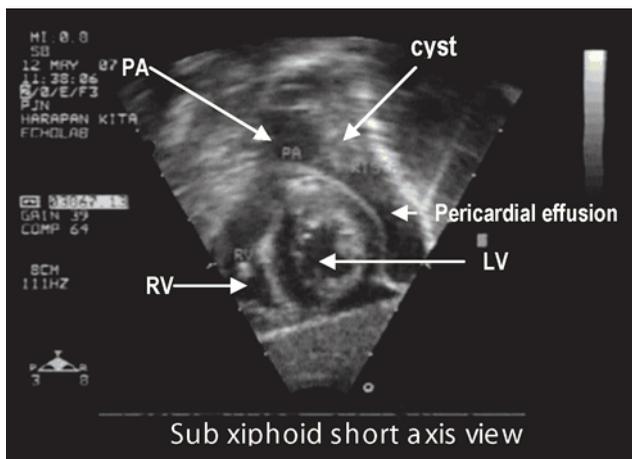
Echocardiography Subxiphoid short axis view showed pericardial effusion and cyst in the pericardial cavity
